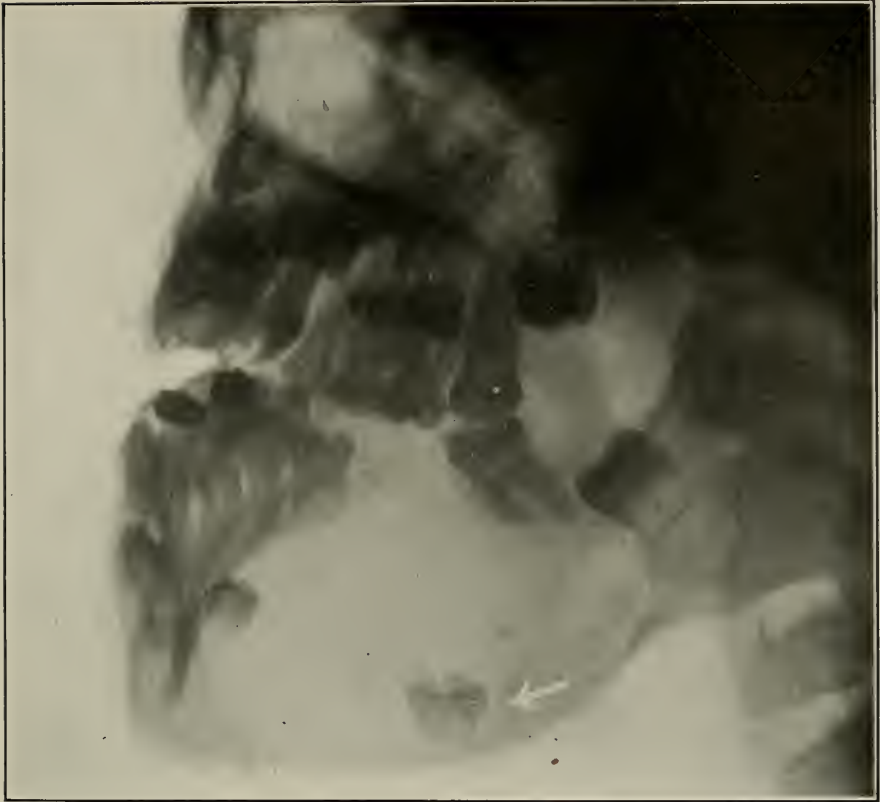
Dentigerous cyst of the lower jaw in child nine years old. The arrow points to the tooth in the cyst. The light area represents the cyst. (Radiograph by Pancoast, of Philadelphia.)
